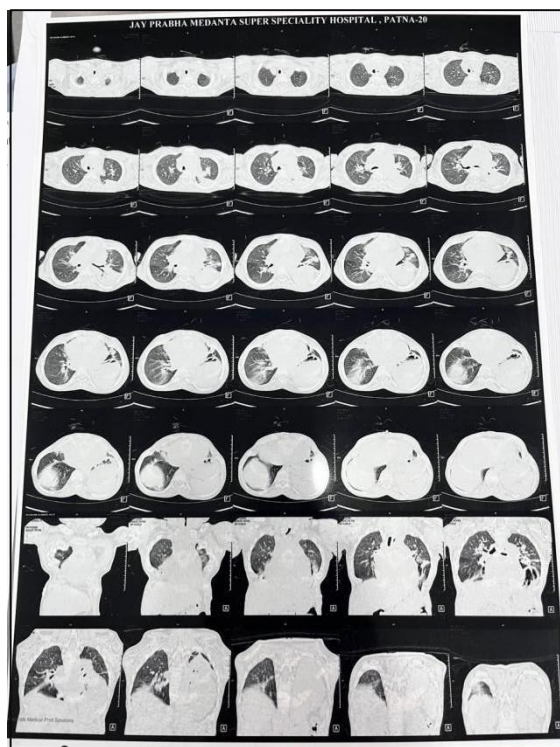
HRCT chest showing pulmonary consolidation with subsegmental collapse and associated kyphotic vertebral deformity.
